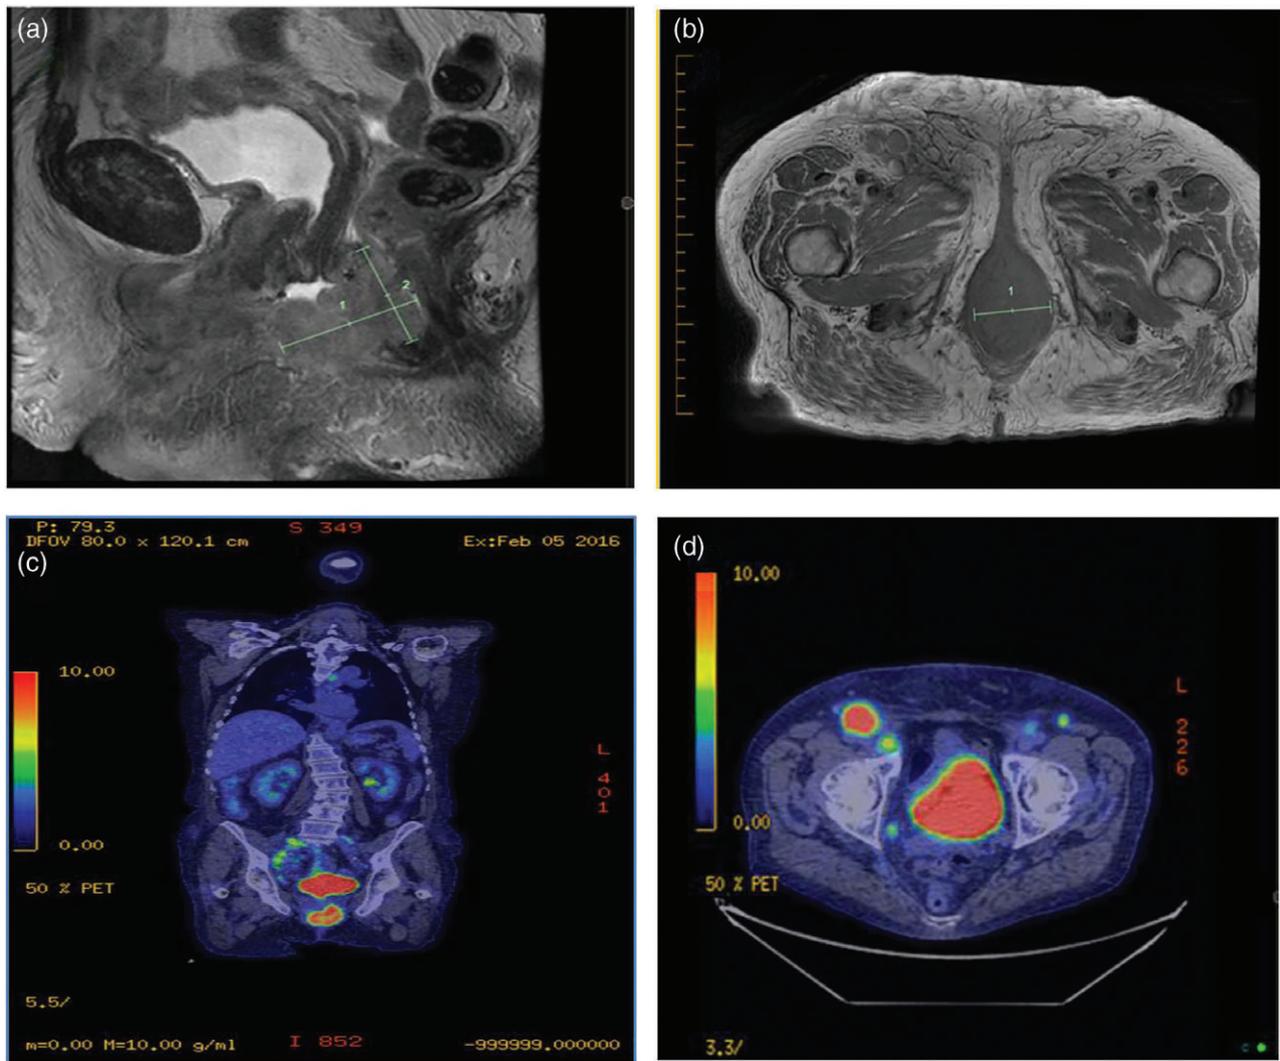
(a and b) Pelvic MRI showing a perineal mass on the lower half of the vagina (c) & (d) FDG PET scan shows an intensely avid pelvic mass, with multiples avid nodes above and below the diaphragm.
